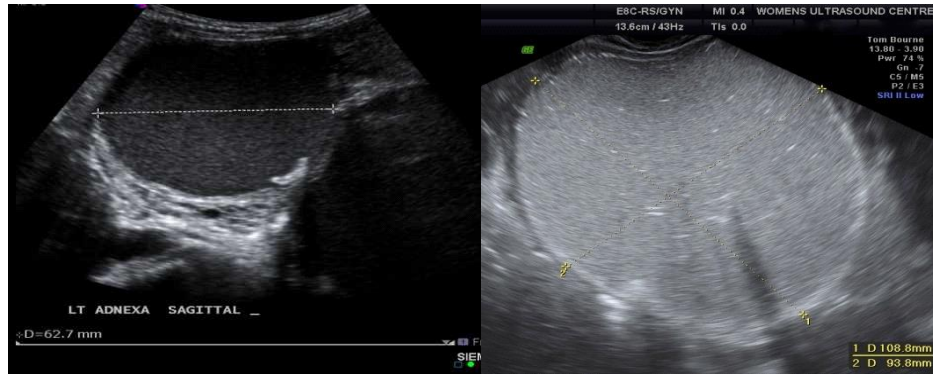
Ultrasound image for Endometriosis (Steinkeler et al, 2009)
